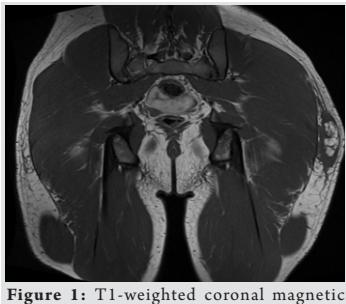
T1-weighted coronal magnetic resonance imaging slice showing the fat fracture in the adipose tissue between the subcutaneous tissue and fascia of the left thigh.
